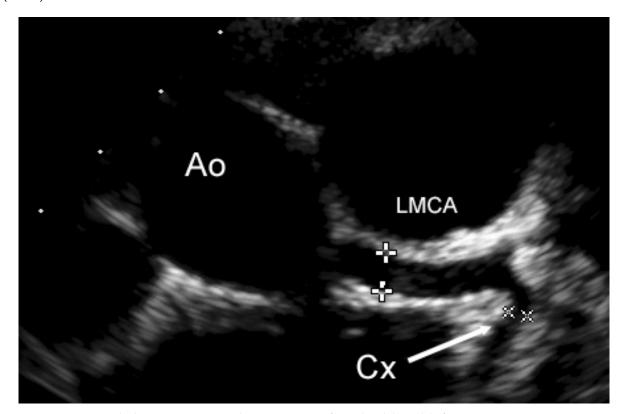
Parasternal short axis view showing a uniformly dilated left main coronary artery (LMCA, 4.7mm) and dilated circumflex artery (Cx, 3.4mm). Ao = aorta
